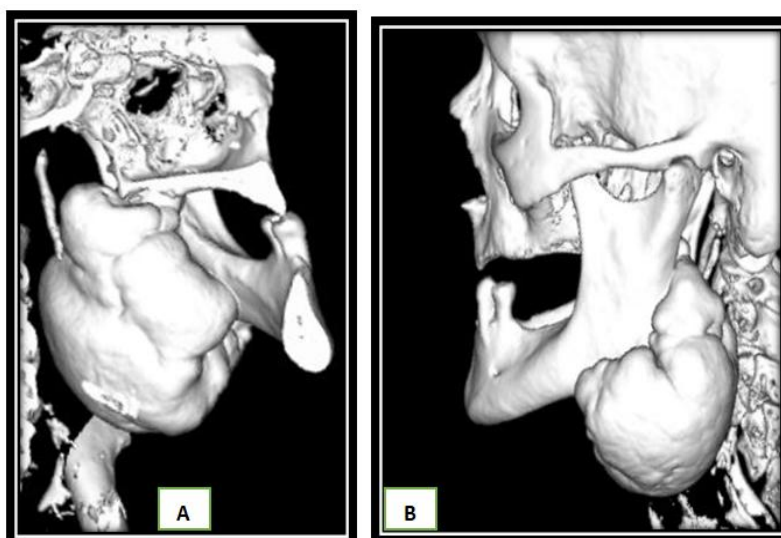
Medial (A) and Lateral (B) view of three-dimensional CT image shows a bony mass arising from the angle of left mandibular
